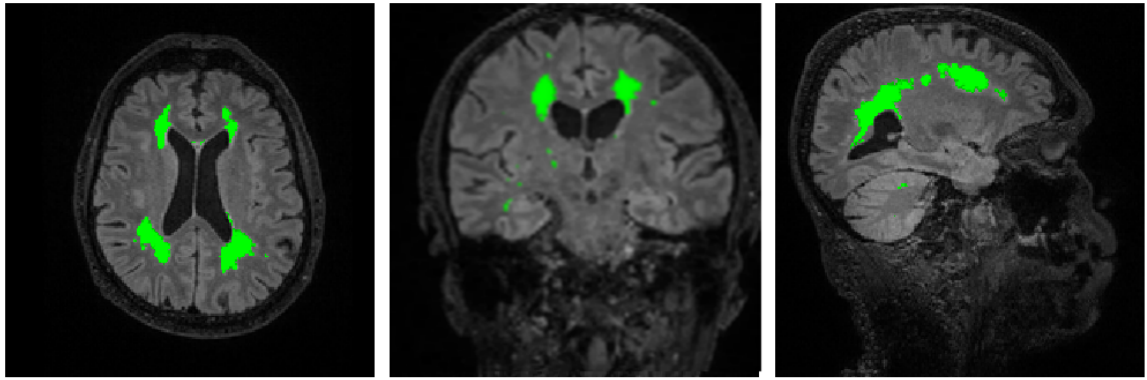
Axial (left), coronal (middle) and sagittal (right) FLAIR MRI with segmentation (bright green) of white matter hyperintensities
